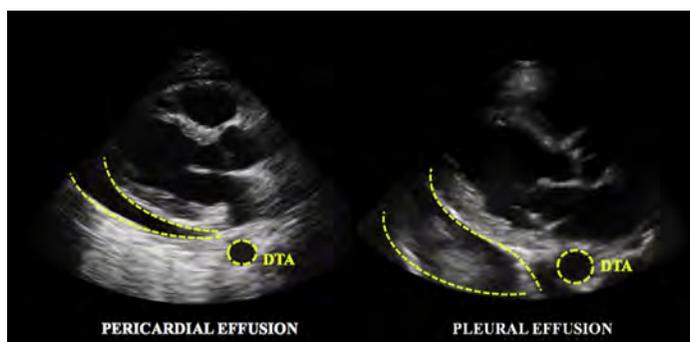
Echocardiographic appearance of pericardial effusion versus pleural effusion in parasternal long axis view. Pericardial effusion follows a plane that is anterior to the DTA, whereas pleural effusion is posterior.
